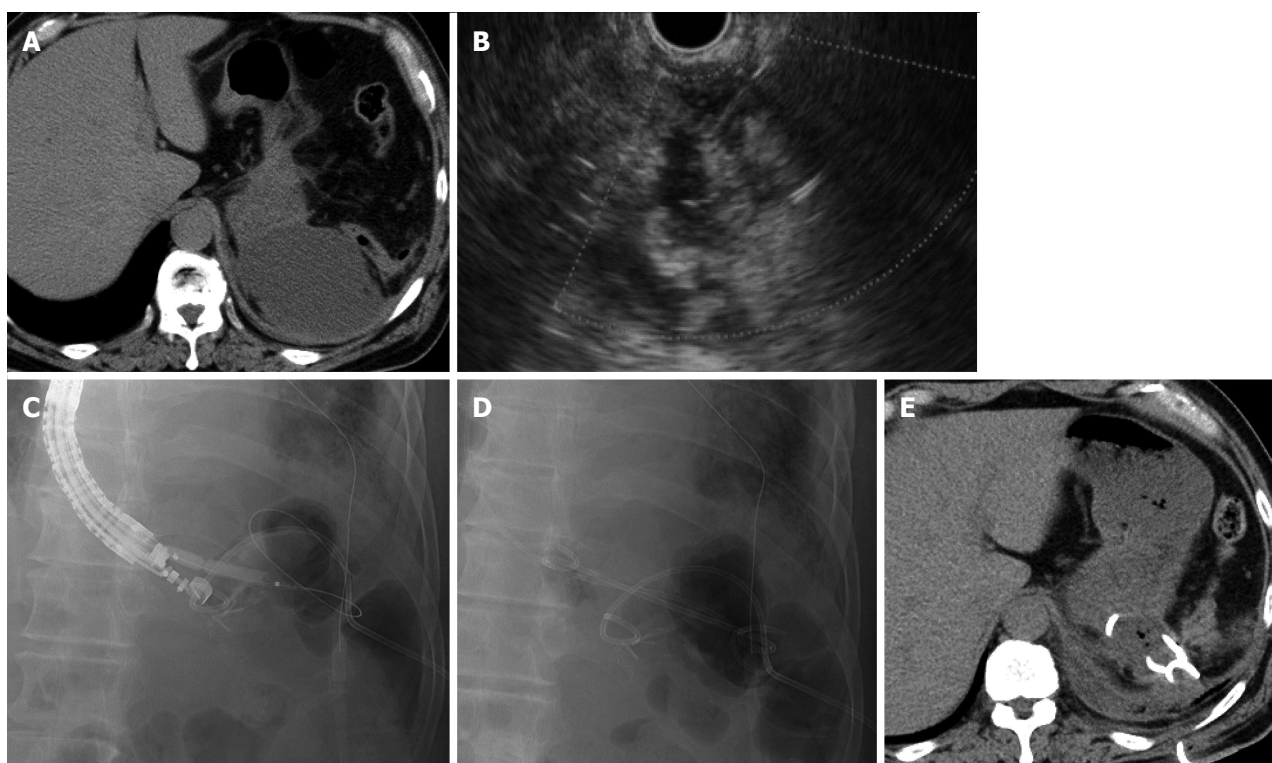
Case 4. A: Computed tomography (CT) reveals fluid collection at the dorsal side of the fornix close to the gastric wall; B: Endoscopic ultrasound (EUS) showing the fluid collection, which was punctured by a 19-gauge needle; C and D: Fluoroscopy image showing placement of the percutaneous drain and insertion of the 6-mm balloon catheter over the guidewire. Both a 7-Fr double pigtail stent and a 6-Fr nasal biliary catheter are placed; E: Ten days after EUS-guided drainage, CT reveals that the fluid collection decreased.
